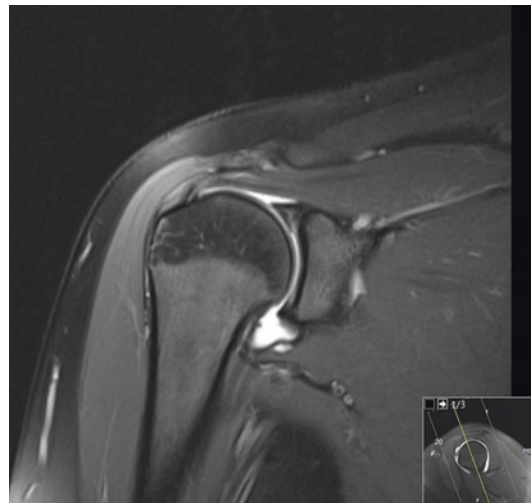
Coronal MR image demonstrating superior labral tear
